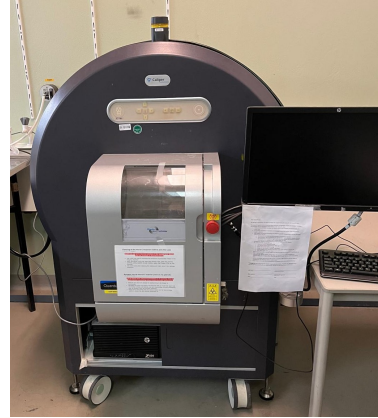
Quantum FX  $\mu$ CT machine
